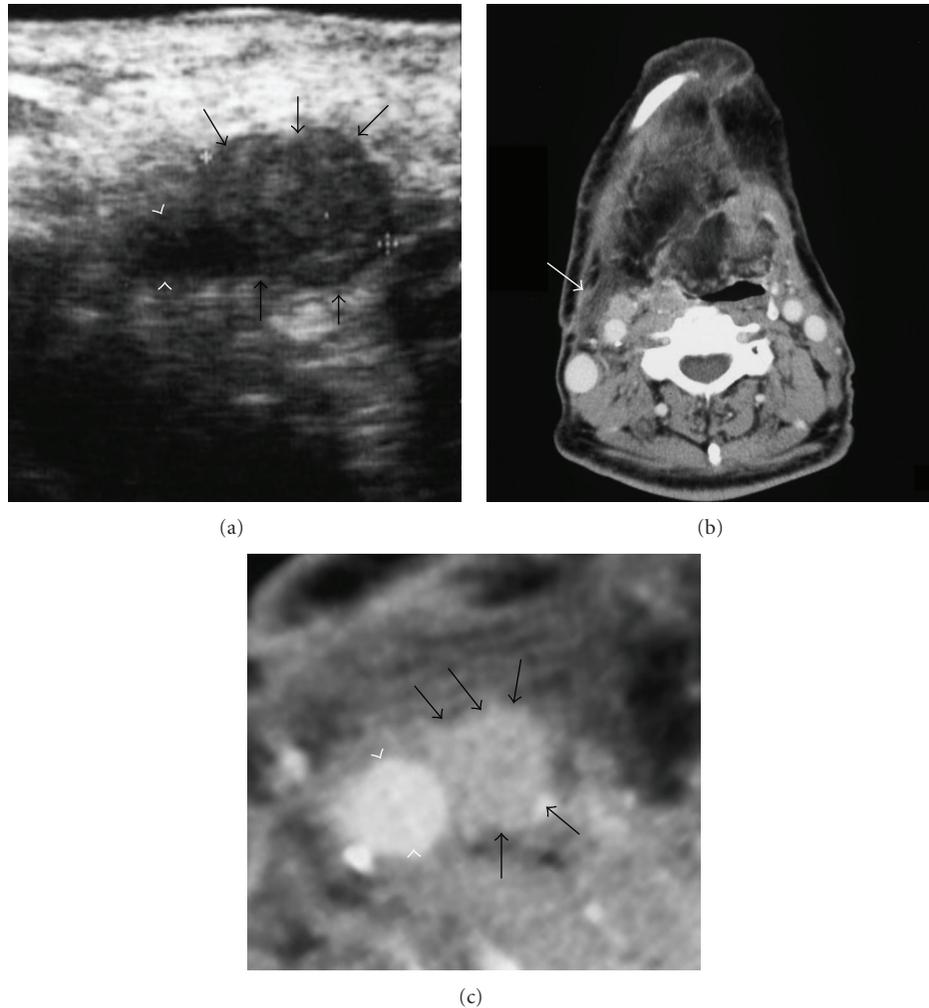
(a) B-mode in ultrasonography around the right superior internal jugular vein of a 69-year-old man with carcinoma on the right side of the tongue. The metastatic lymph node (arrows) contacts the common carotid artery (white arrowheads). (b) Computer tomography (CT) images of the same patient shown in Figure 3(a). The arrow indicates the same regions of B-mode in ultrasonography. (c) Magnification of CT images in area around arrow of Figure 3(b). The metastatic lymph node (arrows) contacts the common carotid artery (white arrowheads).
